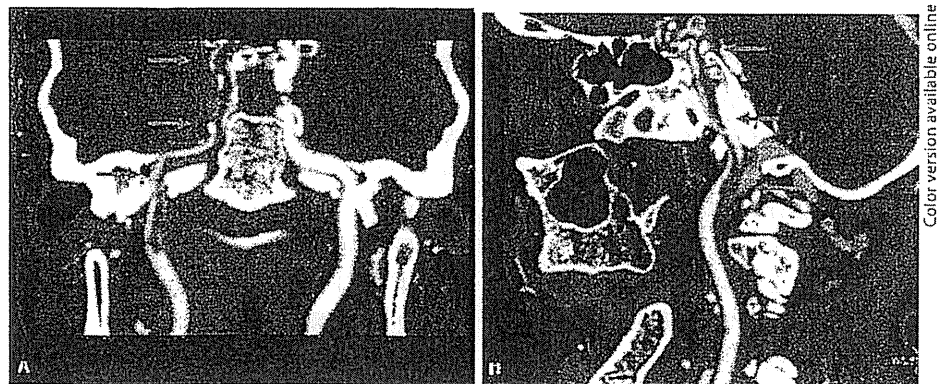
Intra- and extracranial angio-CT. Coronal and lateral projections showed a large thrombus in the right internal carotid artery (arrows, red in the online version).
